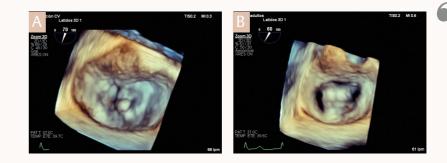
3D echocardiography of the mitral valve before (A) and after (B) implantation of two PASCAL Ace implants.
